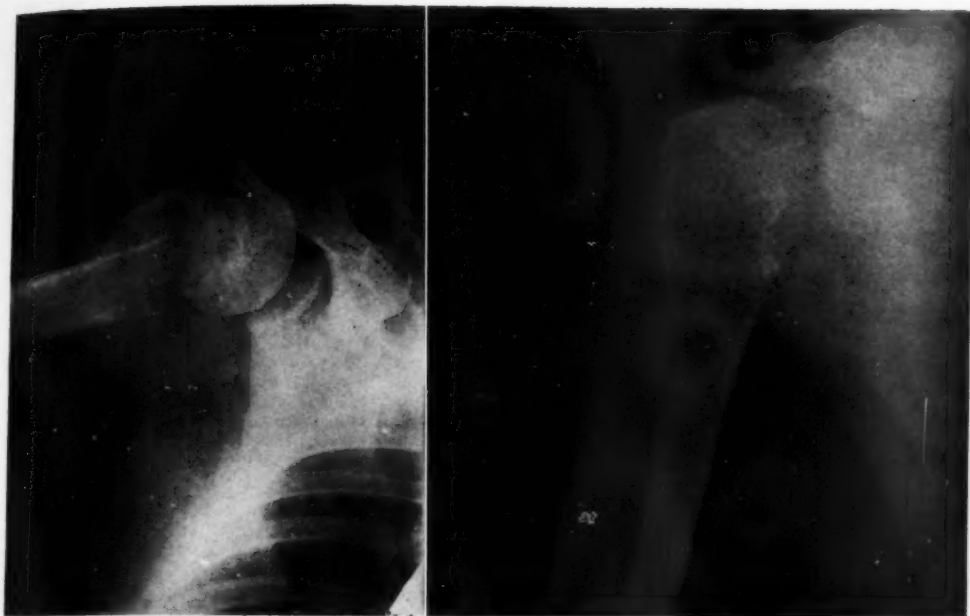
Adenocarcinoma: Metastasis in right humerus before and after x-ray therapy. There was a two-month interval between the examinations. This is one of the exceptional cases where bone and calcific union took place following irradiation.
